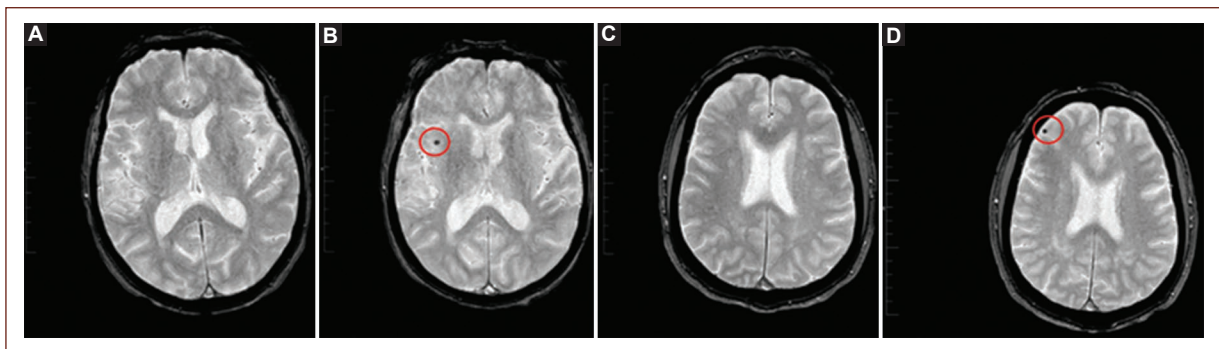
A: brain magnetic resonance imaging study with gradient echo sequence, performed 24 h before insertion of the right carotid stent. No significant findings were seen in the supratentorial sections. B-D: a red circle indicates a punctate area, compatible with a focal hypointensity in susceptibility weighted imaging area located in the right hemisphere, performed 24 h after carotid stenting. No relevant clinical symptoms were observed in this patient.
